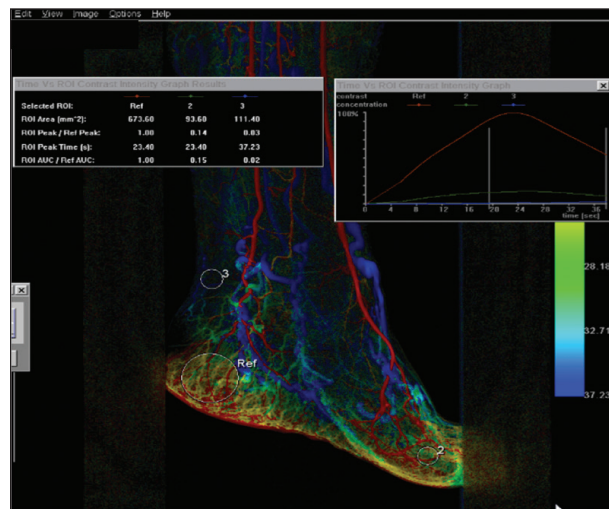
Two-dimensional CT perfusion study used to calculate optimum imaging delay for a 3D perfusion study. Note the plateau of tissue contrast concentration in the measured ROI between 20 and 24 seconds. Based on this study, an injection delay for the 3D perfusion study of 20 seconds was selected.
